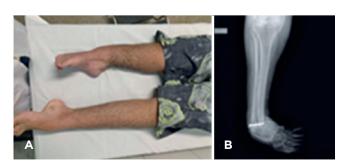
(A) Clinical aspect of deformity and shortening of the right lower limb (shortening of approximately 9 cm, with the right foot in cavo-adducto-varus) (B) anteroposterior radiography.
